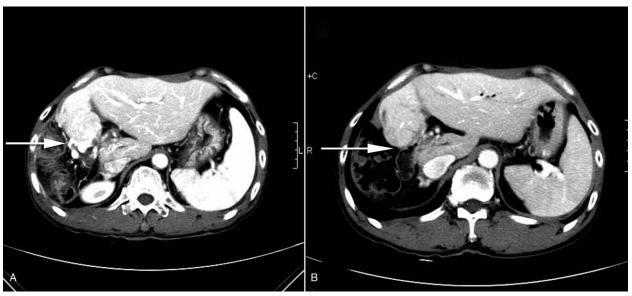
The varicose vein disappeared after the operation. (A) Preoperative MDCT. White arrow, varicose vein. (B) Postoperative MDCT. White arrow, non-varicose vein. MDCT=multidetector computed tomography.
